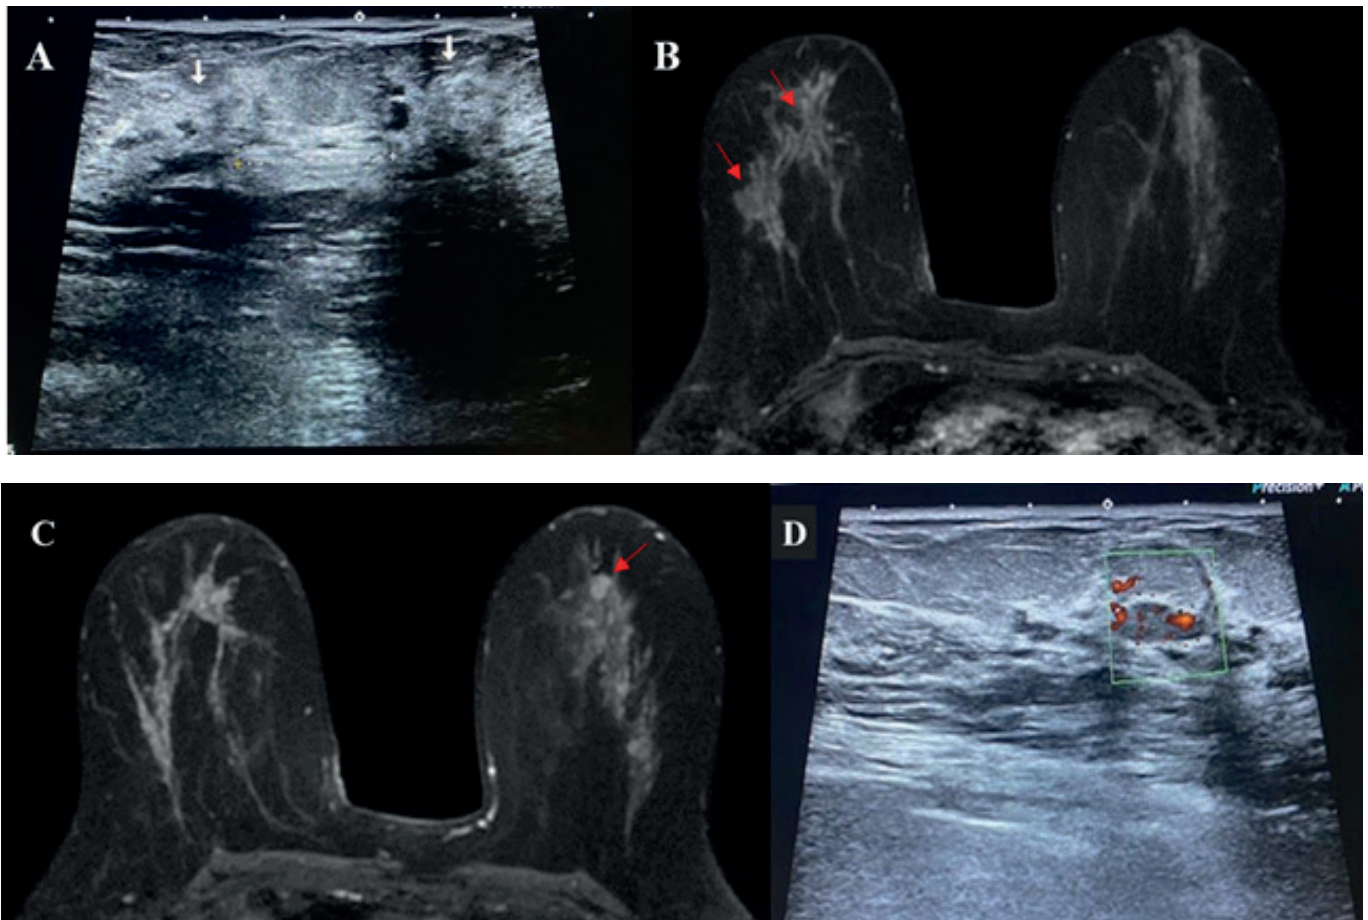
Abbreviations: SLUS: Second Look Ultrasonography, BI-RADS: Breast Imaging Reporting and Data System.
